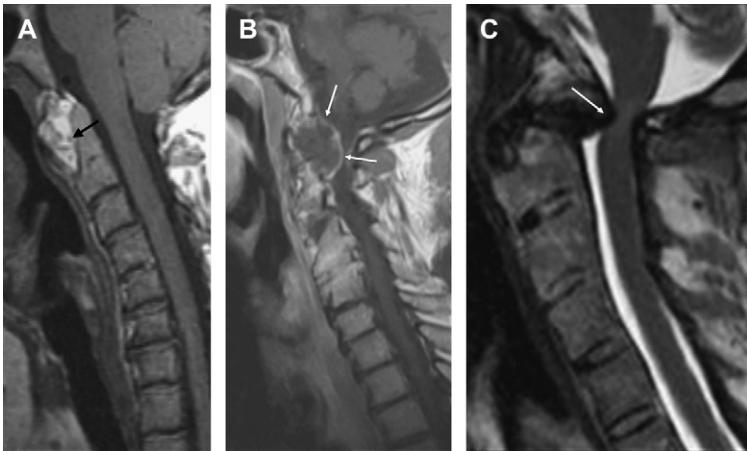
Atlantodental and upper cervical spine disease. (A) Rheumatoid arthritis. Sagittal T1 post contrast—predental enhancing pannus (arrow). (B) Pseudopannus sagittal T1 post contrast—retrodental degenerative soft tissue hypertrophy with compression of the cord. Dorsal rim enhancement (arrows) likely related to epidural venous plexus. The soft tissue was calcified on CT (not shown). Patient was asymptomatic. (C) AS. Sagittal T2 dental fracture and compromise of the foramen magnum (arrow).
